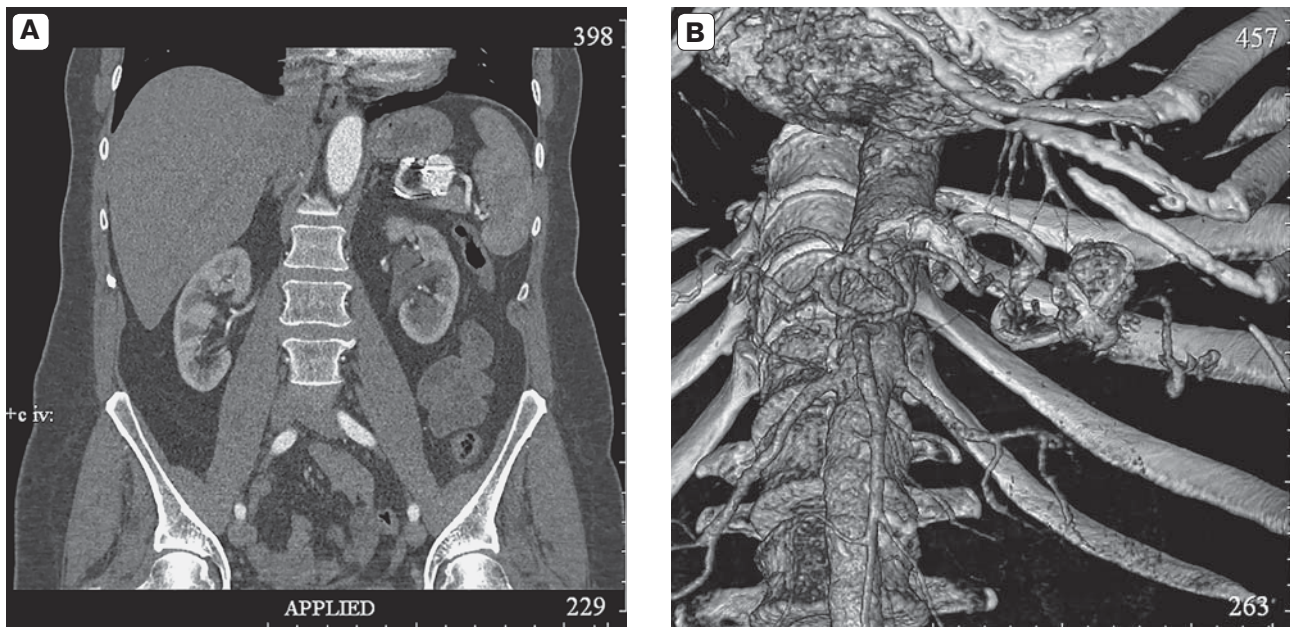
CT-angiography dated October 05, 2015. A, B – status after embolization of the SA aneurysm with evidence of growth up to 28×27 mm and retrograde blood flow.
